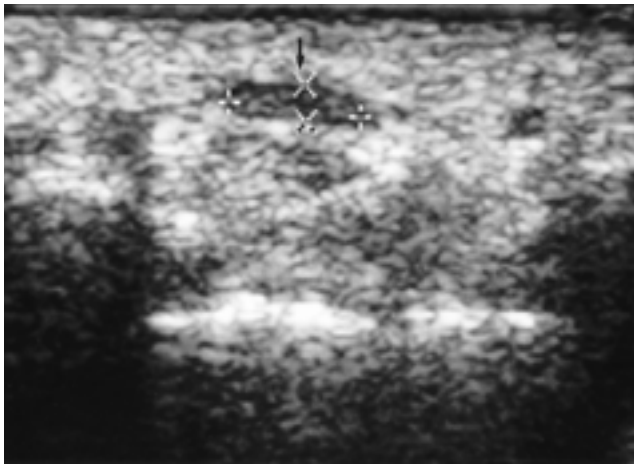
A 52-year-old woman with carpal tunnel syndrome. Axial sonogram at hamate level shows increased flattening of the median nerve (arrow). Flattening ratio of the median nerve is measured as 3.7.
